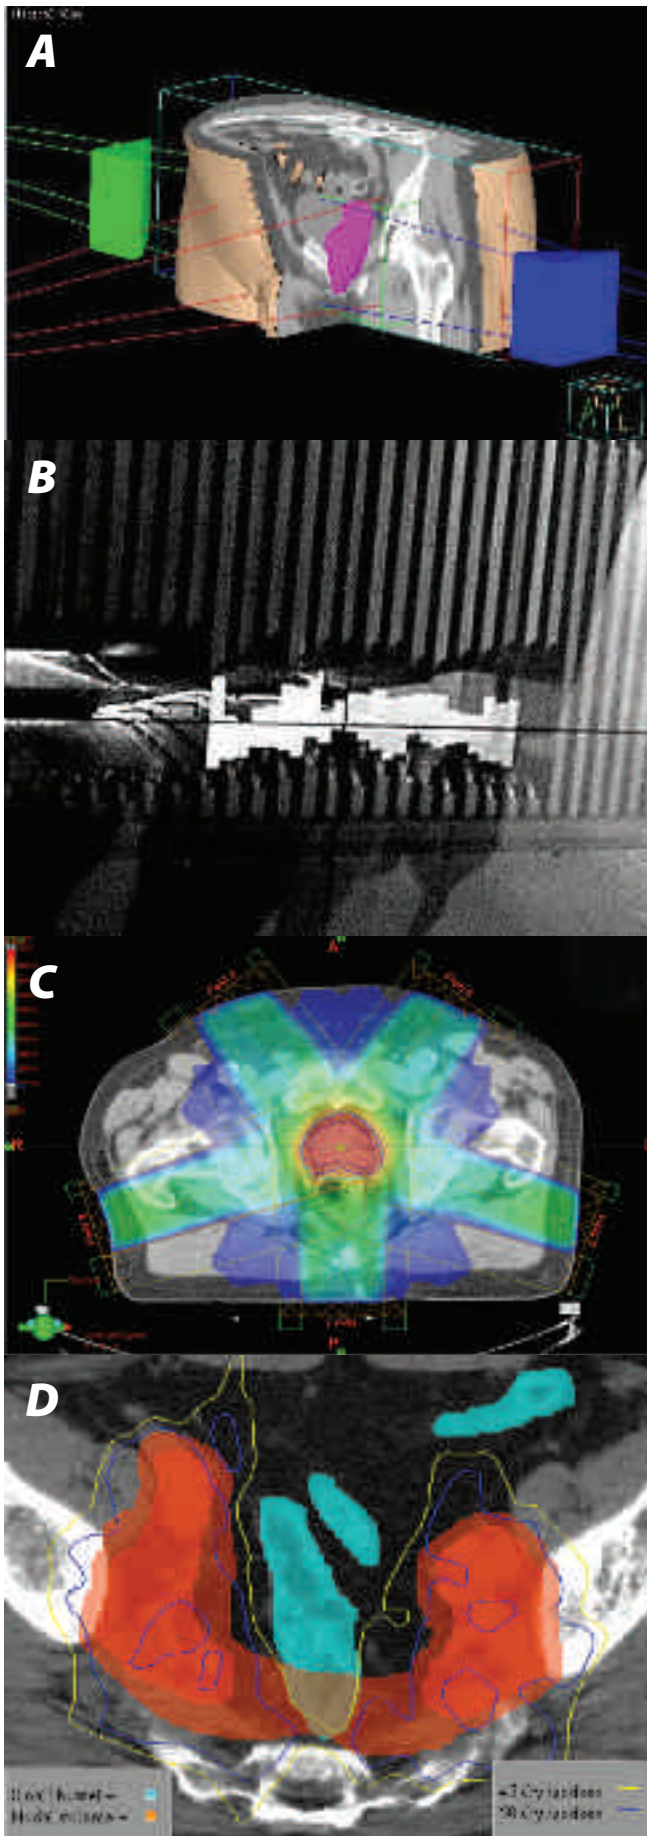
Conformal radiotherapy (CFRT) and intensity modulated radiotherapy (IMRT) in prostate cancer (A) CT reconstruction showing 3 field CFRT beam arrangement to treat the prostate (pink). (B) Multileaf collimator used to shape radiotherapy fields. (C) IMRT plan shaping high dose volume to prostate (red) reducing dose to rectum. (D) Complex IMRT distribution using 5-fields to pelvic lymph node areas (red) reducing dose to bowel (blue).
